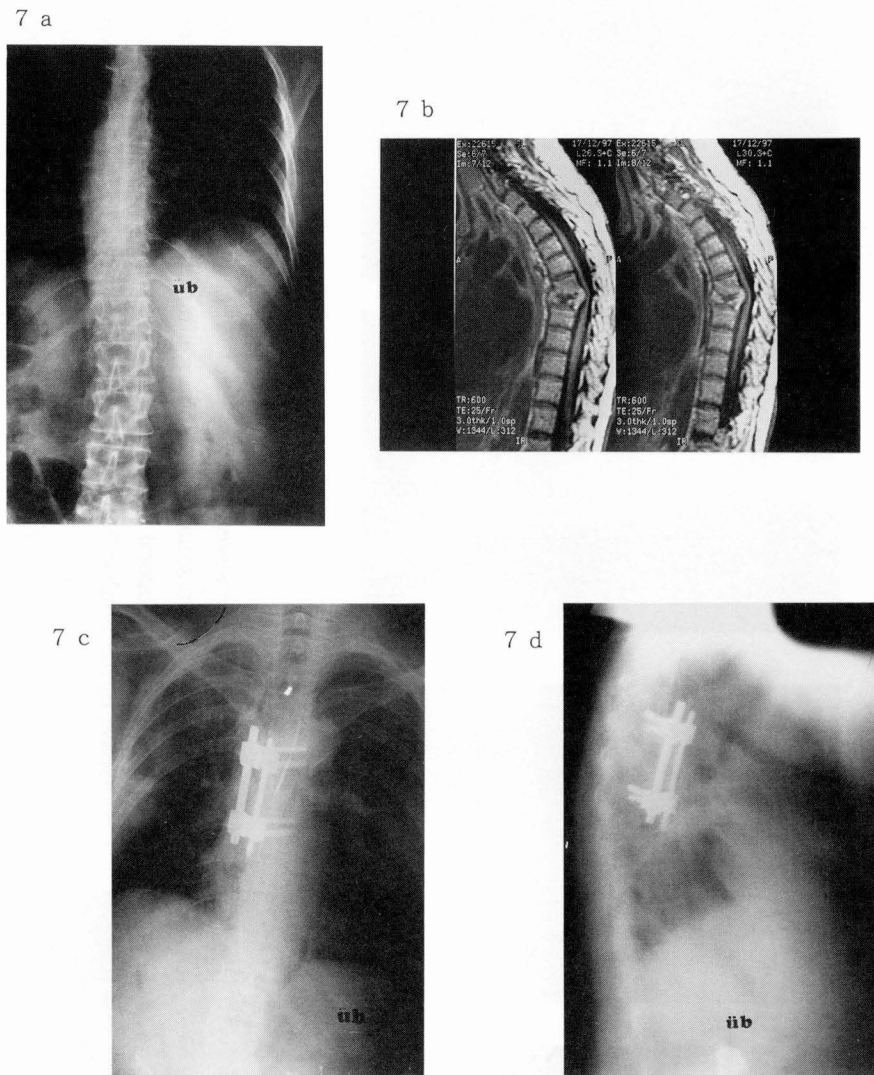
Preoperative posteroanterior (a) and preoperative magnetic resonance imaging sagittal views (b) and postoperative posteroanterior (c) and lateral (d) radiograms of 29 years old male (Ü.B.) with Pott's disease in the 7th - 8th thoracal vertebrae are seen. In the local kyphosis angle, 100 % of correction rate was obtained after anterior debridement and strut grafting followed by anterior CDH instrumentation.
